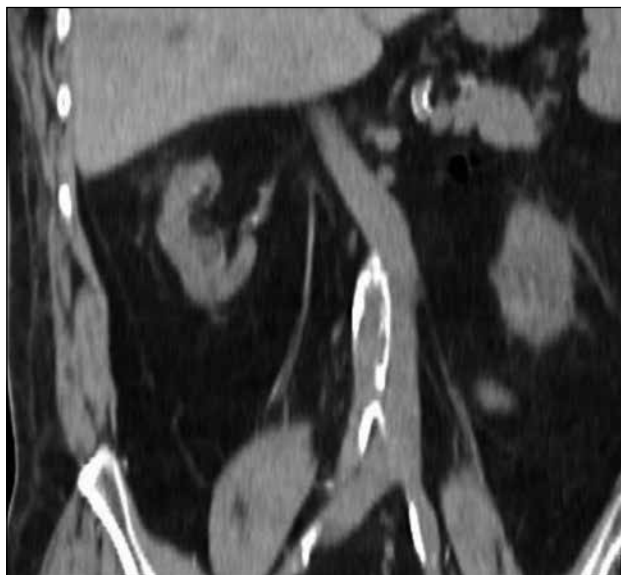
Computed tomography coronal reformatted image of the left inferior vena cava, multiplanar reconstruction.
